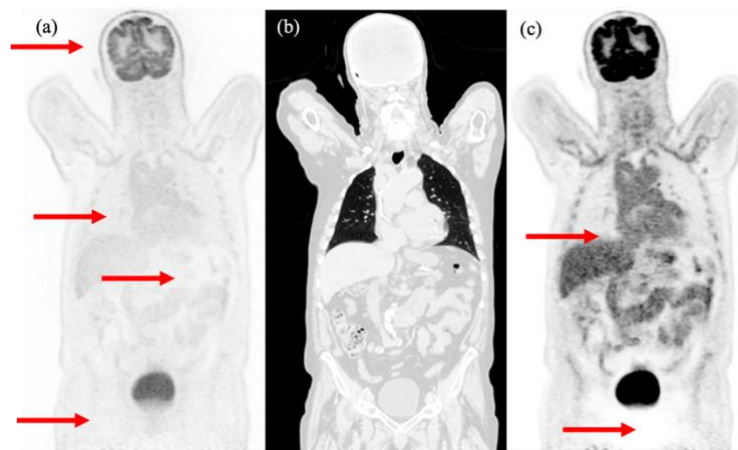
Example of a representative clinical study showing the PET image (a), CT (b), and fused PET/CT images (c). The observed motion and halo artefacts are indicated by the red arrows in the upper and lower parts, respectively.
